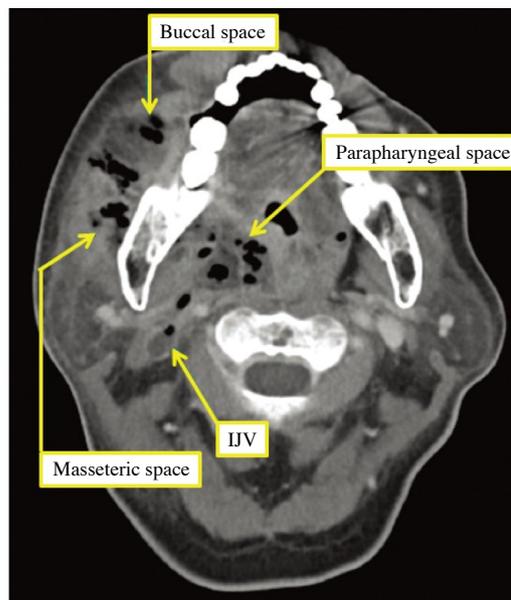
Facial bone CT of the patient in this case: Axial CT with contrast-enhanced image shows low density in the buccal and pterygopalatine space and thrombosis of the right internal jugular vein (Yellow arrow).
